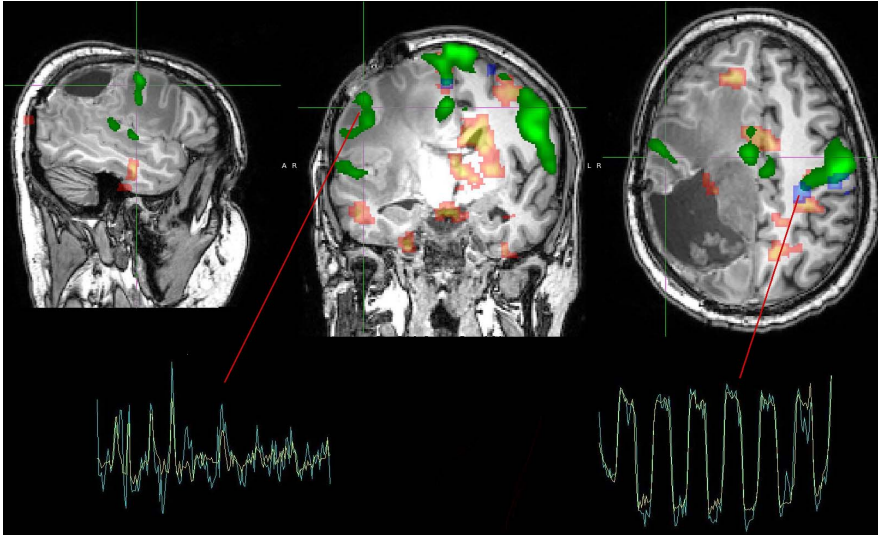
Activation overlays on T1-weighted image. Focus area shows part of the somatomotor network (green), whereas left fingertapping (red-yellow/timeseries on the left) could not be recognized. On the unaffected hemisphere, right fingertapping (blue/timeseries on the right) reveals the expected motor region and overlaps with network information.
